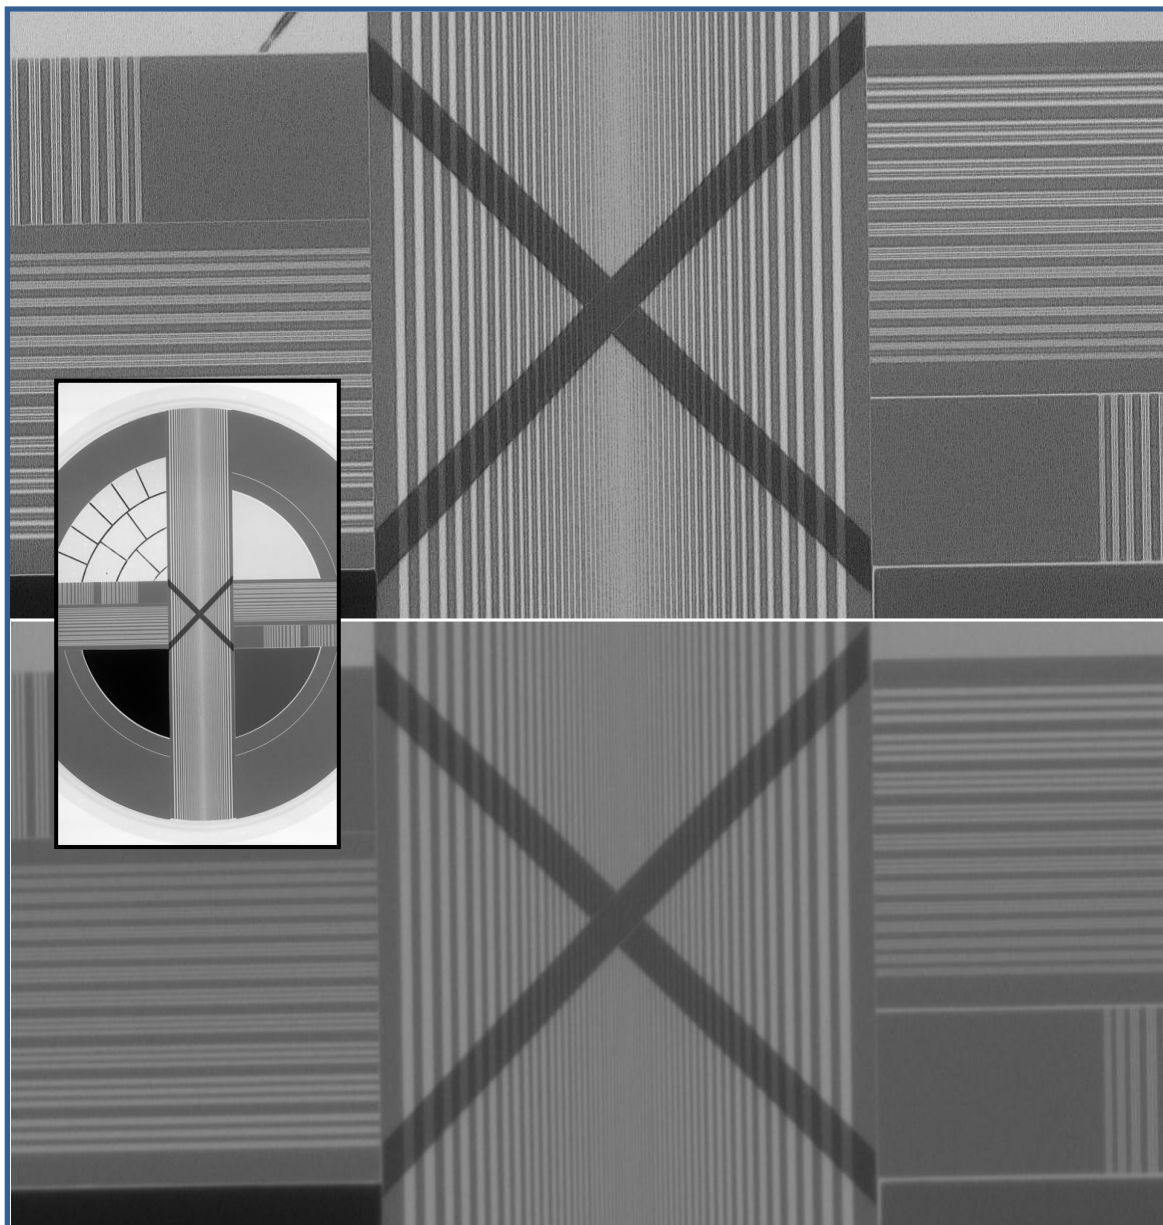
Siemens X-ray test, corresponds to the lungs of an average patient, mode 60kV/20mAs.
